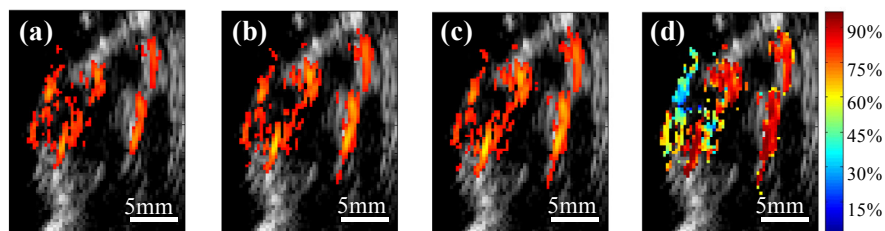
In vivo* co-registered photoacoustic/ultrasound images of the tumor area at wavelength of (a) 750nm, (b) 800nm, and (c) 840nm. (d) The co-registered ultrasound and oxygen saturation ($s\text{O}_2$) image obtained from PAT acquisitions at 14 different wavelengths.
